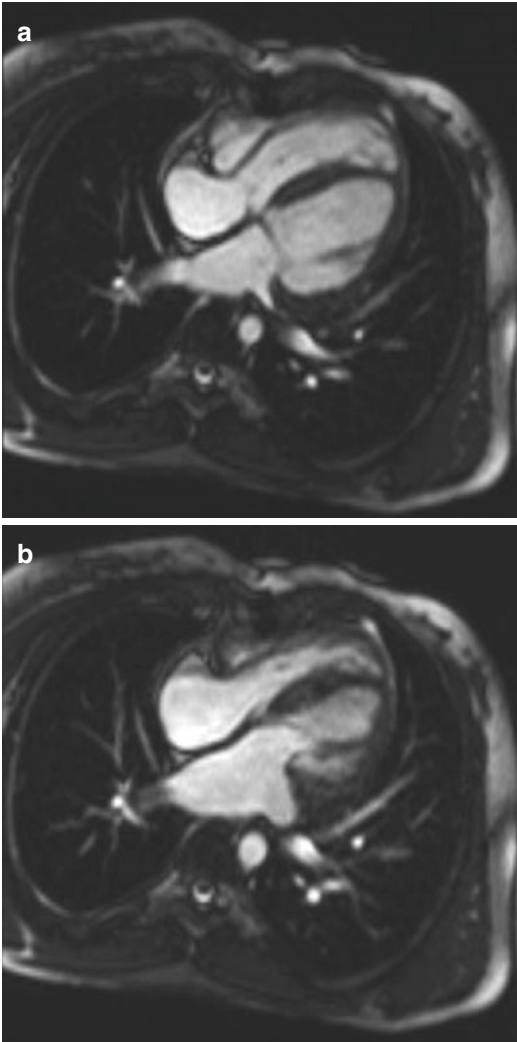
Postoperative complete atrioventricular septal defect with stenosis of the mitral valve. (a), (b) Four-chamber view images of cine TRUFISP MRI sequence demonstrate no residual ASD or VSD but a limited opening of mitral valve creating a stenosis with secondary enlargement of the left atrium
